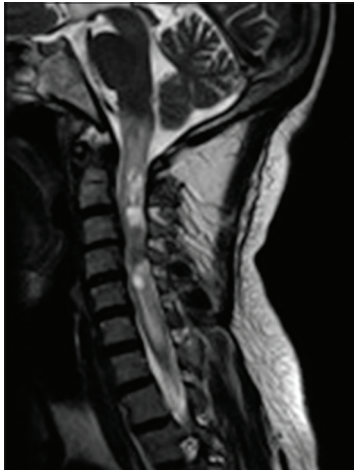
T2-weighted sagittal image showing hyperintense changes from cervico-medullary junction to C7-T1 level, surrounding the relatively isointense tumor at the C3/C4 level
